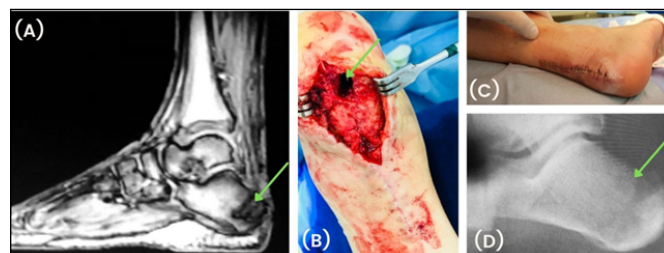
Calcaneus with osteomyelitis treated with bioactive glass S53P4 as a bone substitute: (A) preoperative magnetic resonance image showing osteomyelitis in the calcaneus (arrow); (B) intraoperative image showing the lesion (arrow); (C) image three weeks after surgery; (D) radiography showing bioactive glass S53P4 in the treated bone cavity (arrow) five months after surgery.
